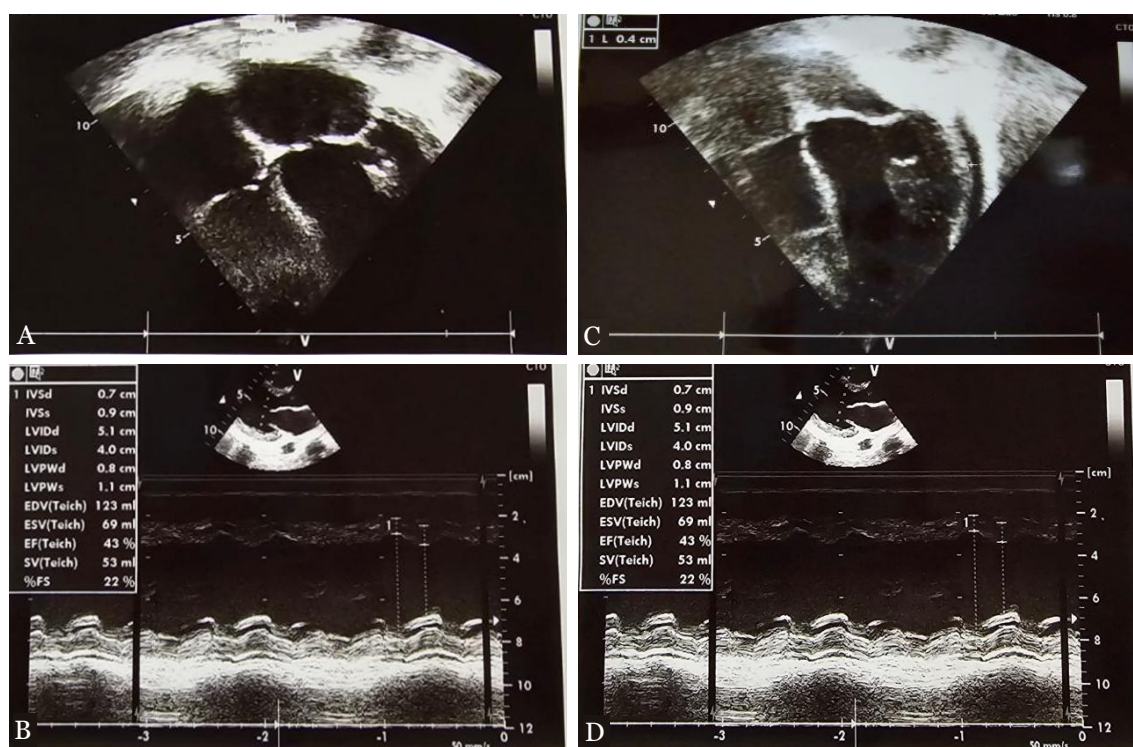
Echocardiography performed one month prior to treatment (A and B) demonstrated dilation of all cardiac chambers with a left ventricular ejection fraction (LVEF) of 43%. Echocardiography conducted one month after treatment (C and D) revealed an increase in LVEF to 53%, indicating improved cardiac function.
